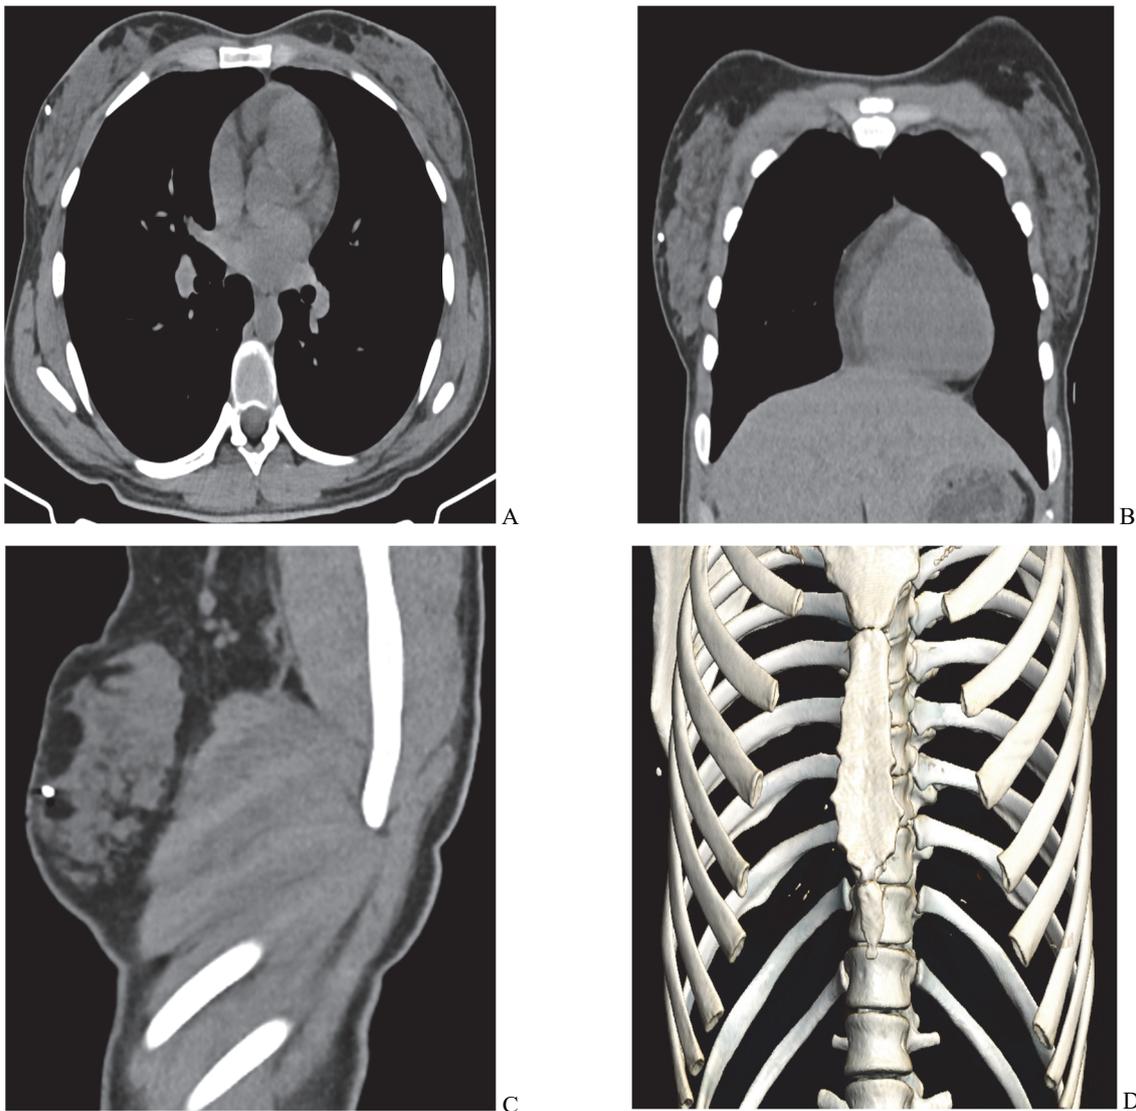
Data of patient K., 27 years, head and chest organs multispiral computed tomography. The 1st day after injury: a foreign body (metal fragment) of metallic density in the right breast with the size 8×7 mm. A – axial projection; B – coronal projection; C – sagittal projection; D – 3D modelling.
